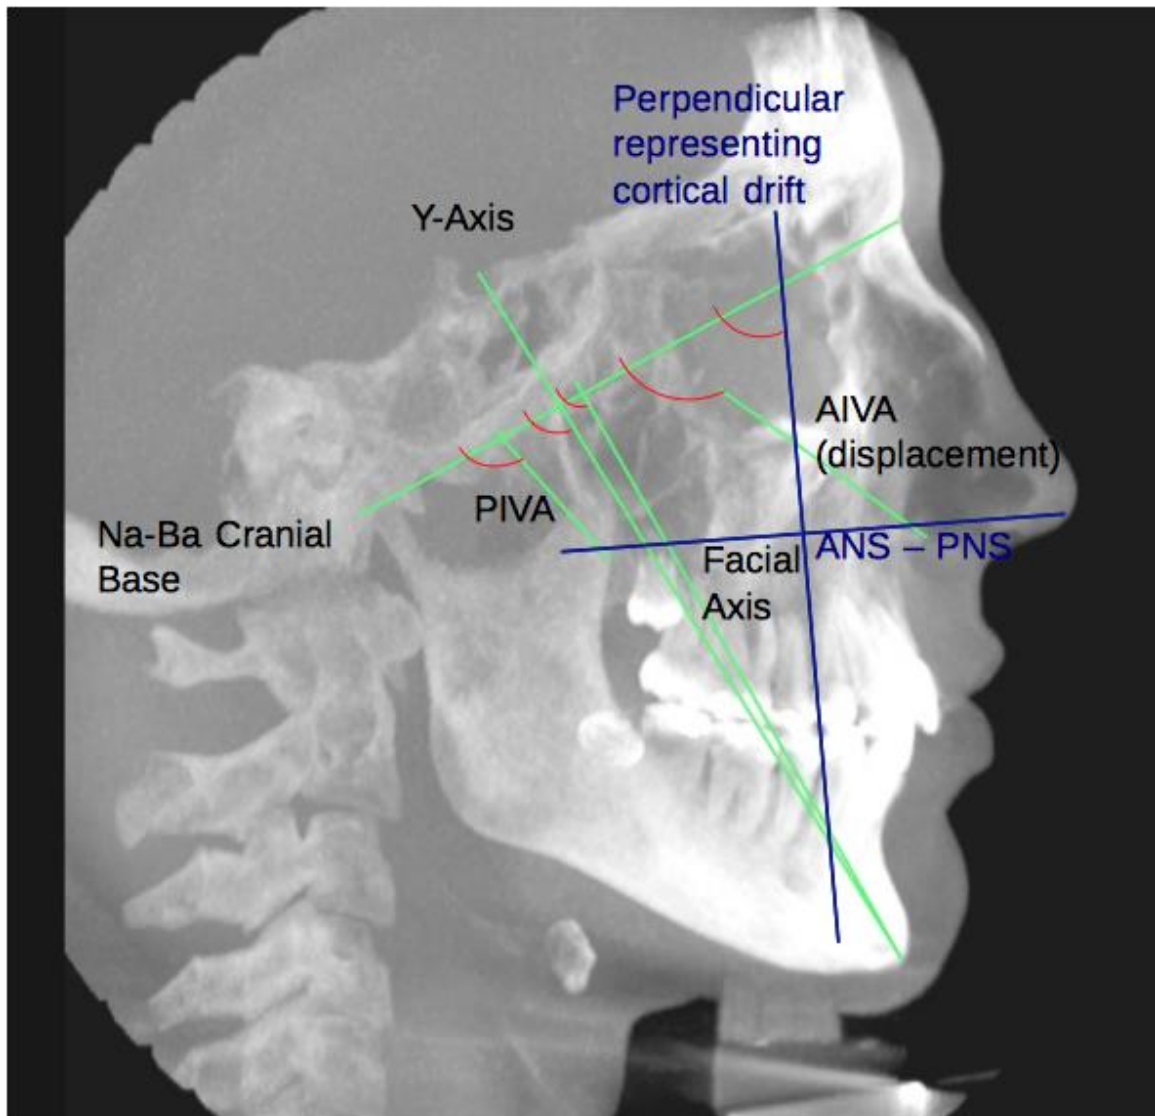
Cortical drift vector shown in blue. The cortical drift vector is drawn perpendicular to the palatal plane (ANS-PNS) shown in blue lines on a CBCT image with reference planes labeled. Na-Ba Cranial Base was the reference plane for measurements of PIVA, AIVA, YA and FA. Red arcs indicate measured angles.
